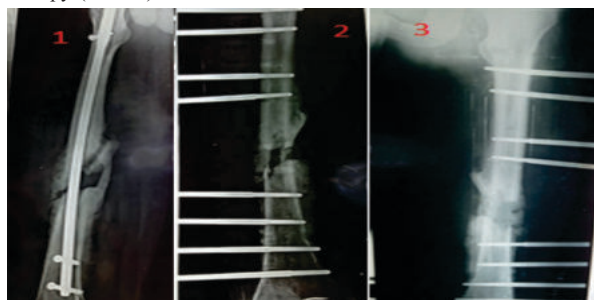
Pretreatment and post treatment radiograph of patient A. Preoperative AP View(1) showing nonunion following fixation with IM Nail. Immediate post operative AP view (2) after nail removal and fixation with L.R.S. AP view at 16 weeks (3) showing union.
